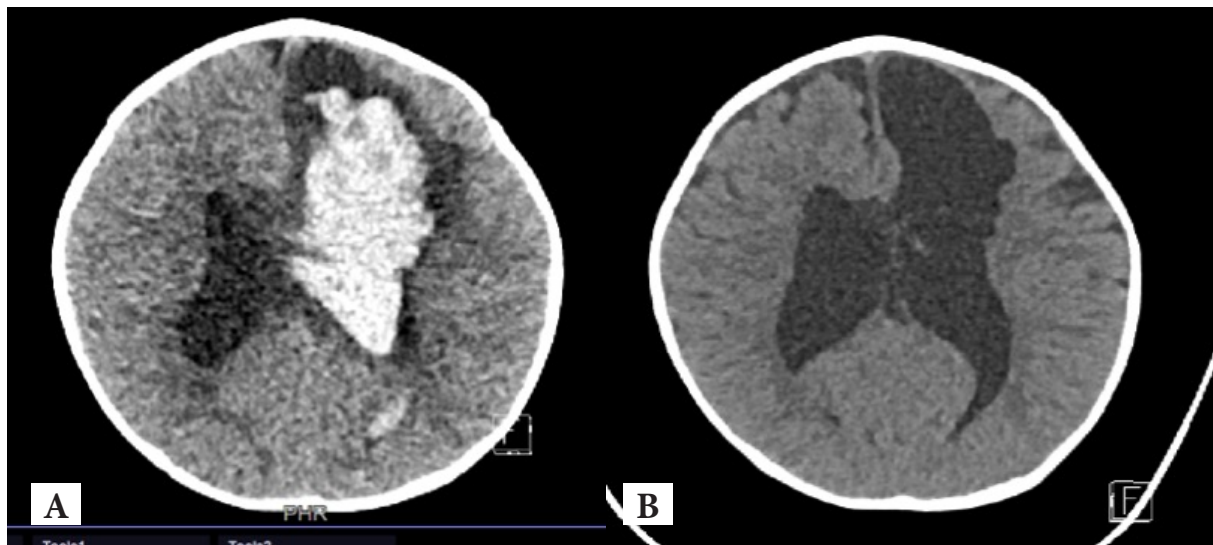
(A) CT brain performed 17 months prior to current presentation shows left frontal intraparenchymal bleeding (white arrow) with intraventricular extension and hydrocephalus (black arrows). (B) Current CT noted evidence of left frontal encephalomalacia in the corresponding region.
